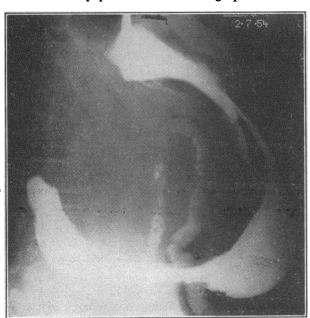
A large pseudo-pancreatic cyst displaces the stomach forwards in this barium-meal lateral radiograph. The patient had a fatal cardiac arrest during the performance of cystogastrostomy.
